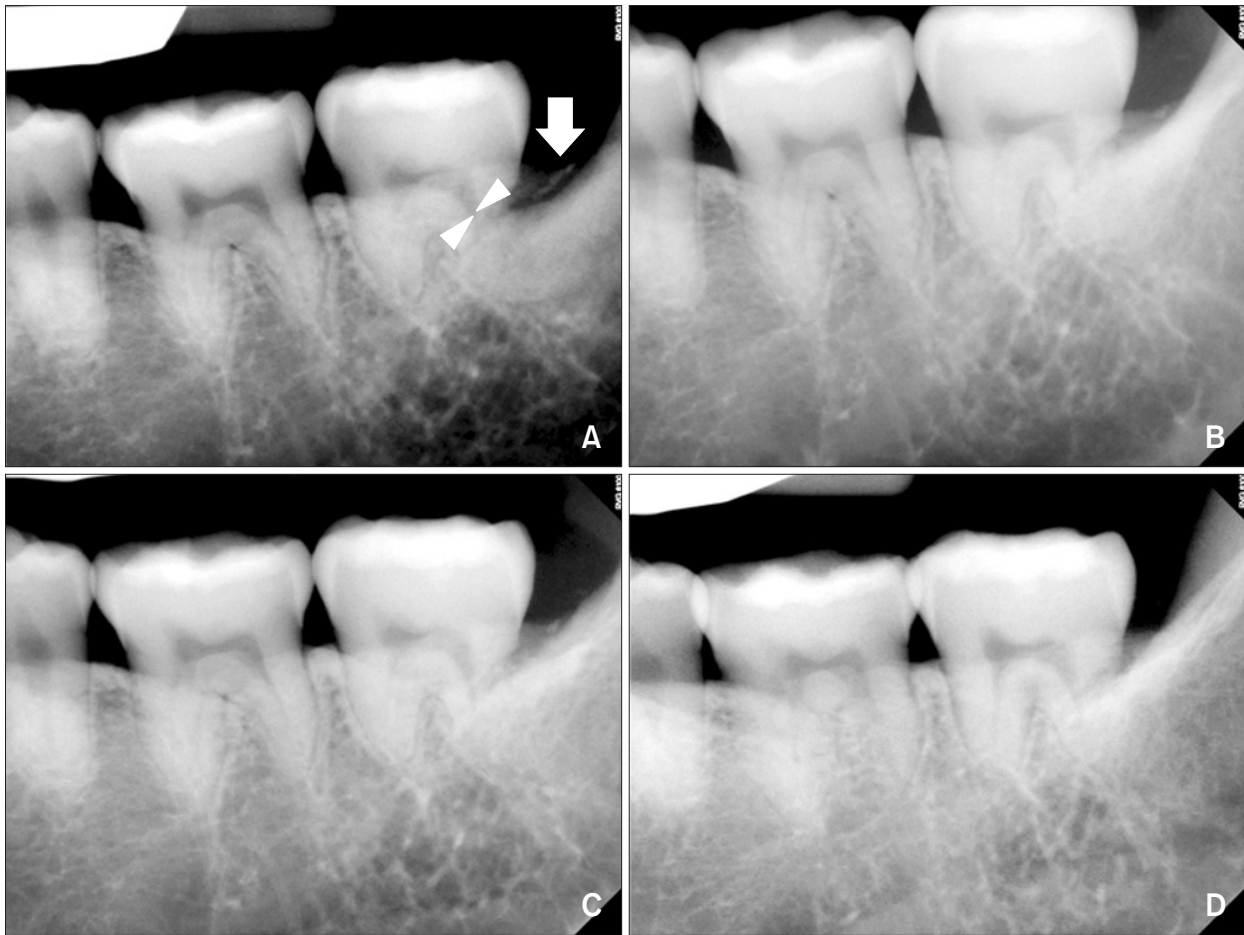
Follow-up periapical radiographs of tooth #37 at 6 months (A), 12 months (B), 18 months (C), and 24 months (D) later. A narrowed root canal (arrowheads; A), implying a canal obliteration at the resorbed root side, along with alveolar bone healing (arrow; A), were observed 6 months after the removal of tooth #38.
